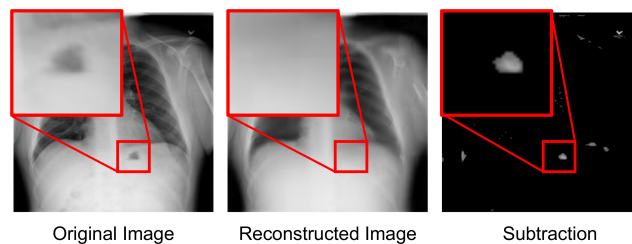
MAE could reveal anomalies. We input a chest X-ray (with anomalies) to the trained MAE and plot the difference map of the reconstructed output and original X-ray. Interestingly, we observe that the MAE happens to “heal” those anomalies by replacing them with normal patterns.
